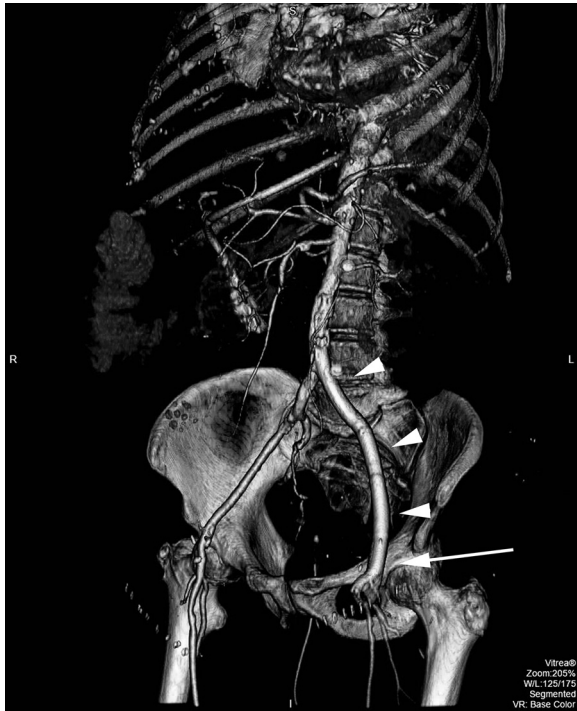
Three-dimensional reconstruction of postoperative computed tomography scan of the hybrid stent and bypass graft repair. The *arrowheads* point to Viabahn covered stents; the *arrow* shows the polytetrafluoroethylene graft material anastomosed to the native common femoral artery (CFA).
